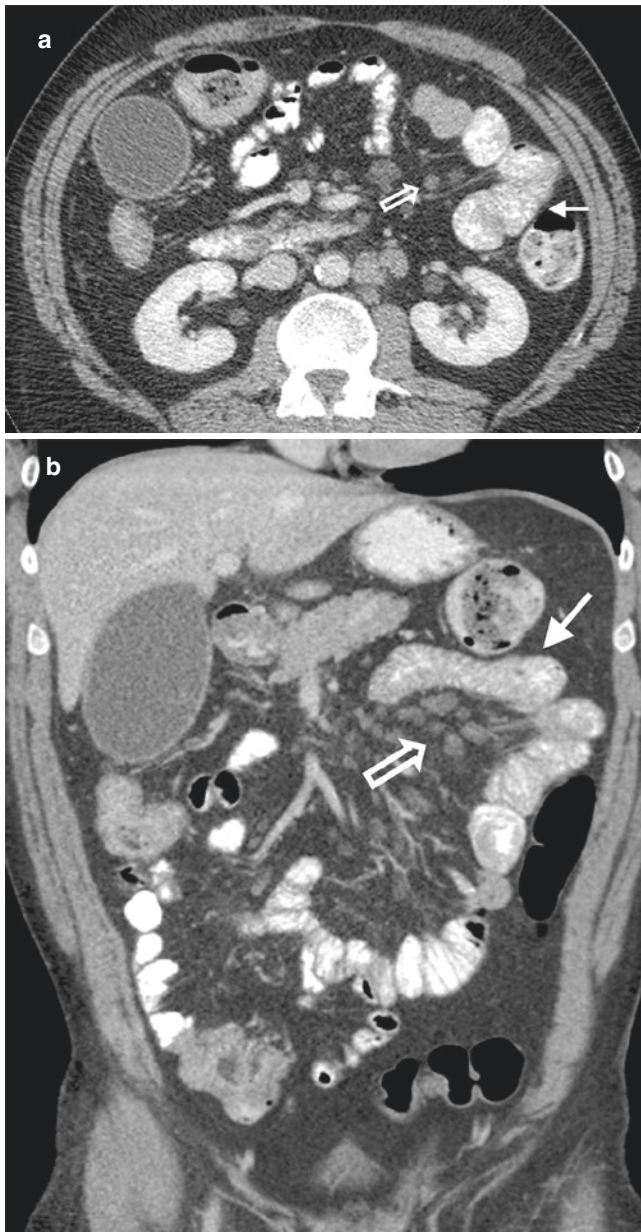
Whipple's disease. Axial (a) and coronal (b) CT images in a patient with Whipple's disease, displaying characteristic nodularity of the duodenal and jejunal folds (solid arrows), along with multiple prominent low attenuation mesenteric lymph nodes (hollow arrows)
